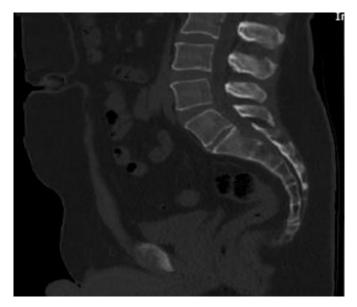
Sagital CT scan shows a mass in the spinal canal with scalloping at posterior of S2 vertebral body without any bone invasion
